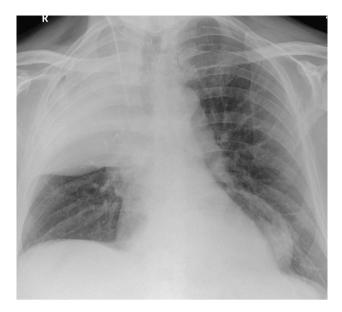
Initial AP erect chest radiograph showing right upper lobe consolidation and a bulging horizontal fissure consistent with lobar pneumonia. There is an incidental hiatus hernia behind the heart.
